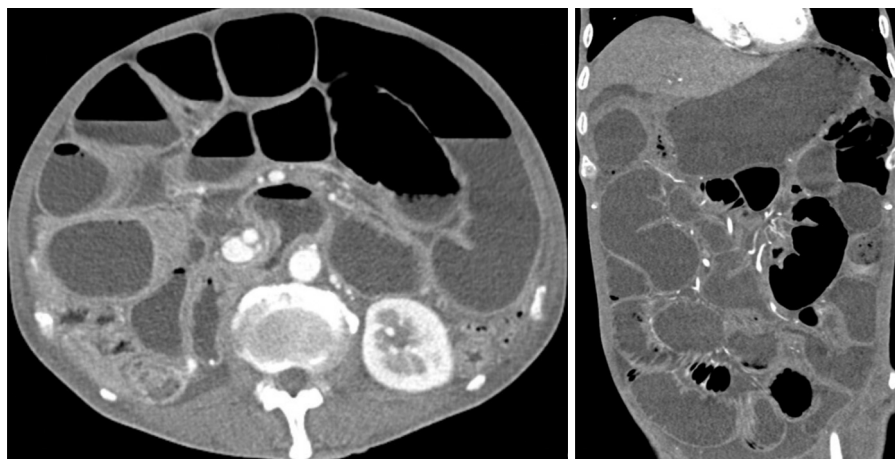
Computed tomography enterography showed remarkable expansion of whole small intestine with 5.4 cm in width and gas-liquid levels, with enhanced mucosa and no evidence of stenosis.
